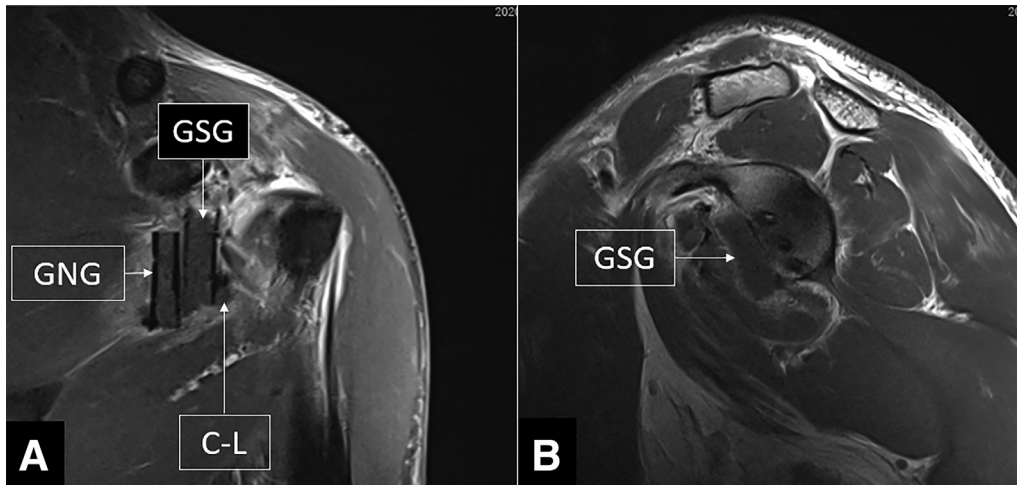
Postoperative oblique coronal view (A) and oblique sagittal view (B) of MRI of the left shoulder after glenoid bone grafting. Abbreviations: C-L, the reattached capsule labrum; GNG, glenoid-neck graft. GSG, glenoid-surface graft; MRI, magnetic resonance imaging.
